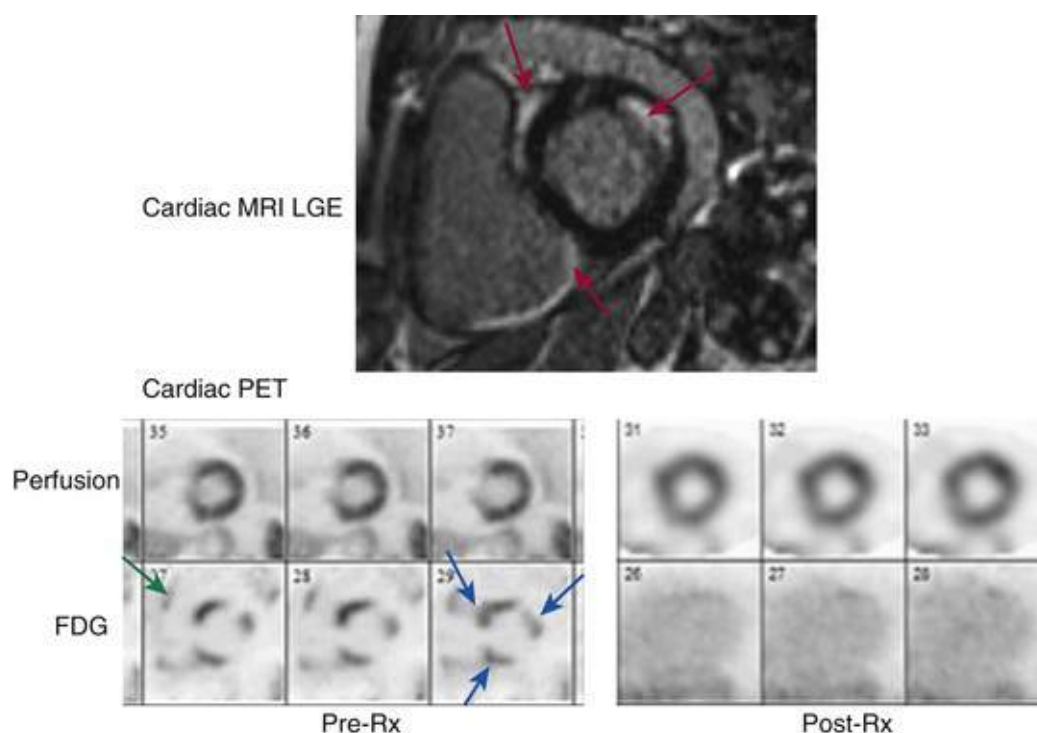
Example of cardiac MRI and PET findings consistent with cardiac sarcoidosis as well as a reduction in myocardial inflammation following immunosuppressive therapy. In a patient with a history of ventricular tachycardia referred for evaluation, cardiac MRI demonstrates a large amount of subepicardial late gadolinium enhancement (LGE) involving the basal anteroseptum and inferoseptum, most prominently at the RV insertion points, as well as subendocardial LGE involving the basal anterolateral wall. (*red arrows*). Note LGE along the basal inferoseptum extending across into the right ventricle. Because these features were strongly suggestive of cardiac sarcoidosis, the patient was subsequently referred for a rest PET scan. After a high-fat diet to suppress ^{18}F -fluorodeoxyglucose (FDG) uptake from the myocardium, there was intense FDG uptake involving the basal anteroseptum, inferoseptum, and anterolateral segments (*blue arrows*), as well as focal uptake of FDG by the right ventricle (*green arrow*). The rest perfusion images show a perfusion defect along the septum, in part corresponding to the areas of FDG uptake involving the septum. The patient was treated with oral corticosteroids, and follow-up PET 1 year later (*bottom right panel*) shows complete resolution of the myocardial inflammation. Notably, the resting perfusion defect also improved because of less inflammation compression on the microvasculature. (Images courtesy Dr. Ron Blankstein.)
